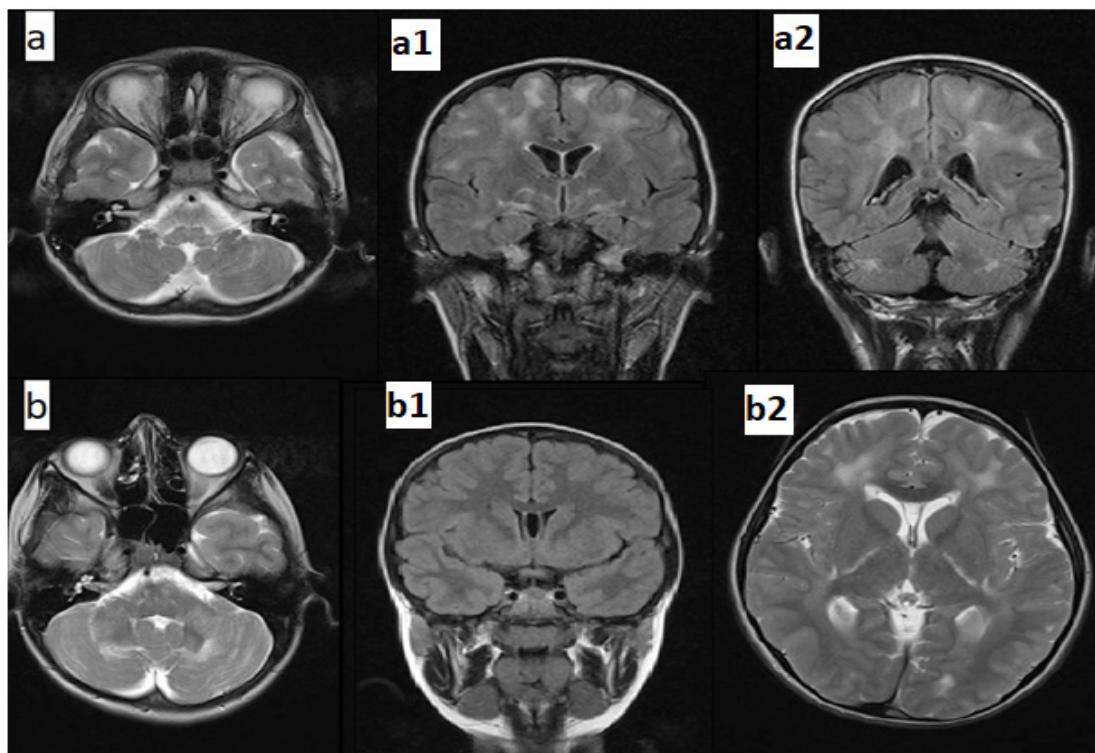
Brain MRI of patients with GAN mutations: Brain MRI of two patients with GAN mutation, cerebellar and cerebral abnormalities observed abnormal hyperintense signal in t2-axial and coronal/ flair sequences. MRI includes (case 1 (14 age). a-a2) abnormal bilateral dentate nuclei and hyperintense signal of the corticospinal system, globus pallidus, capsule interna posterior, and periventricular white matter, (case 3(11 age). b-b2) Variation of cavum septum pellicidum et vergae as well as hyperintense lesions in cerebellar and cerebral white matter.
